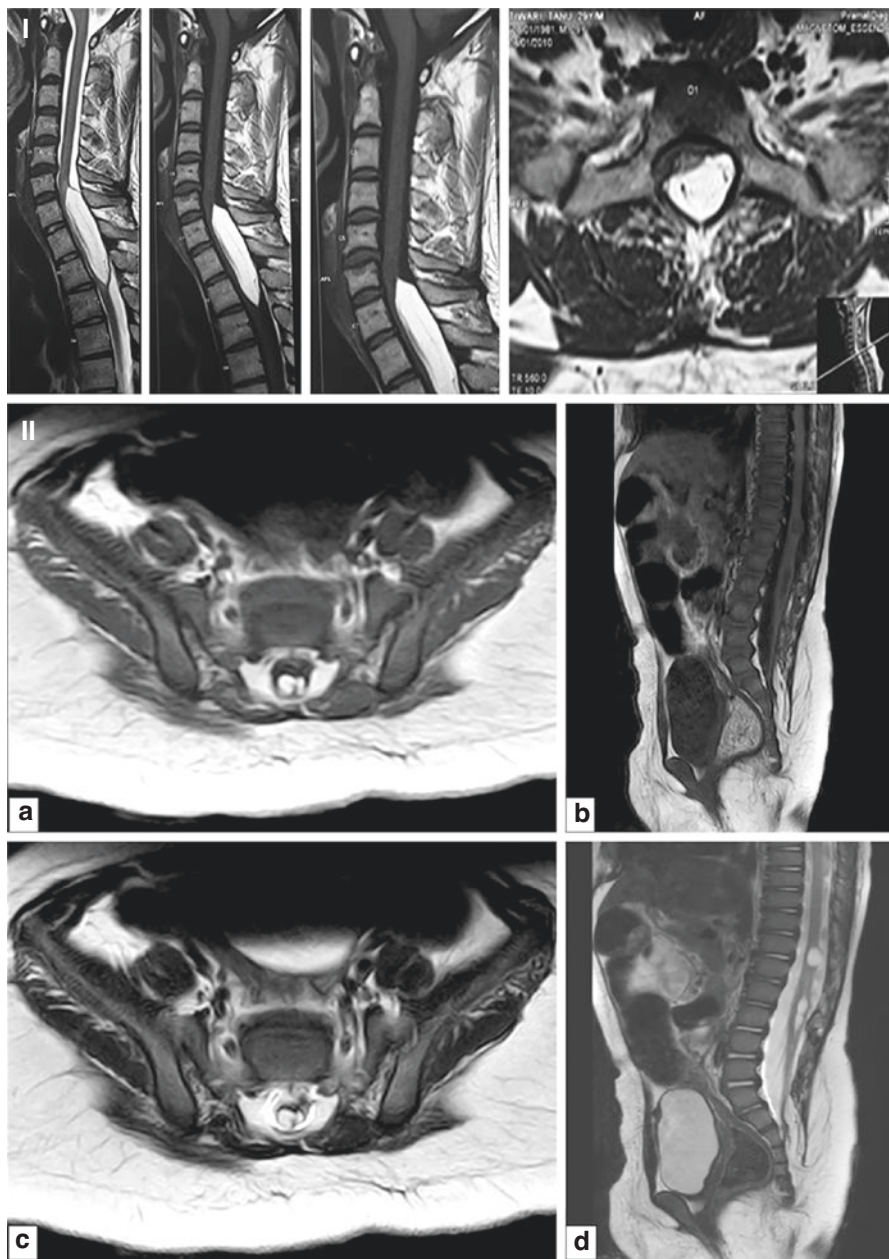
MR images of a case: I: Cervicothoracic Subpial Lipoma II: Conal Lipoma III: Filar Lipoma. I: MRI of cervicothoracic spine (sagittal and axial views) showing cervicothoracic intra-medullary lipoma located dorsolaterally and extending from C6–C7 disc space to D2–D3 disc space level. II: (a, b) T1WI & c, d) T2WI axial and sagittal imaging of lumbosacral spine showing an unformed conus with an intradural lipoma with low lying cord and proximal syringomyelia. III: (a) Sagittal image with conus at level (within normal range) and thick filum. (b) Axial image showing fat within filum
